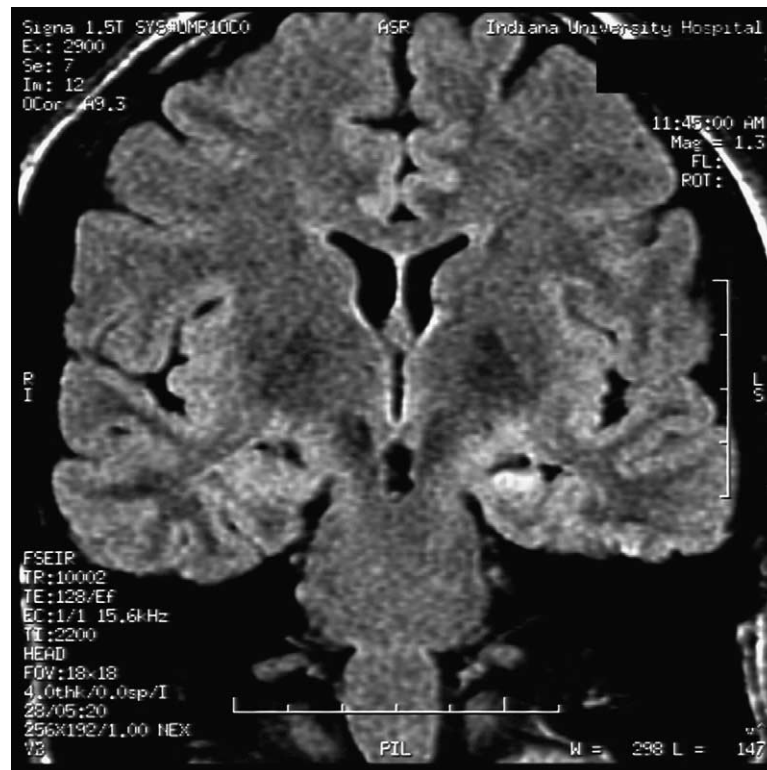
Coronal fast fluid-attenuated inversion-recovery (FLAIR) MRI showing atrophy and increase in signal of the left hippocampus.
